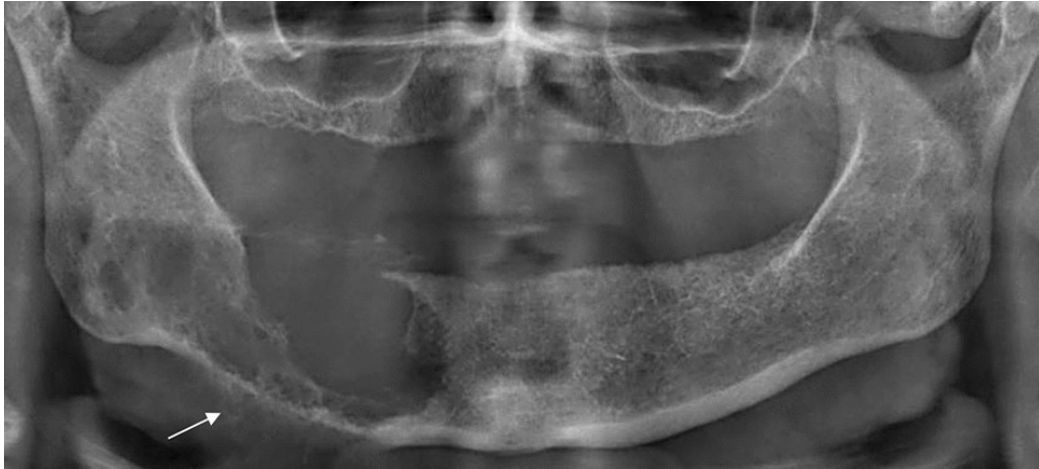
Case 14: Panoramic radiograph showing a poorly demarcated osteolytic lesion in the right mandible with a spiculated periosteal reaction at the inferior border (arrow).
